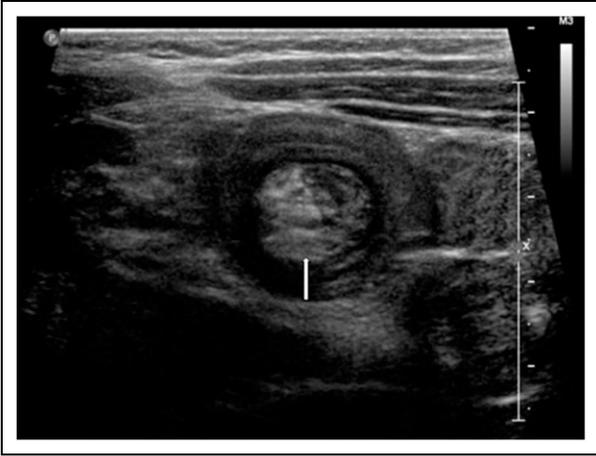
Abdominal ultrasonogram showing small bowel to small bowel intussusception in a patient with Peutz-Jeghers syndrome. Target sign is the layers of the small intestine within the small intestine.
